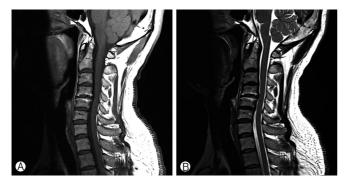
Modic change type II at C4-5 as a high signal in T1- (A) and T2-weighted images (B).
